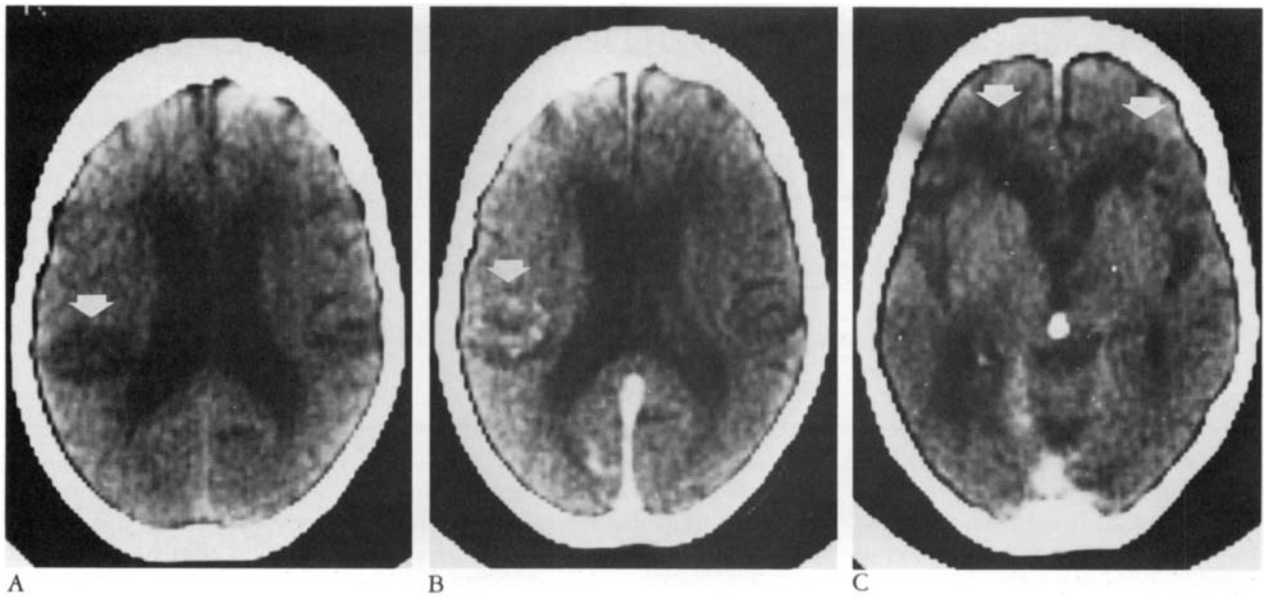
(Patient 1.) (A) Noncontrast computed tomographic (CT) scan at day 70, demonstrating a left parietal infarct (arrow). (B) Contrast CT scan at day 70, showing enhancement of the left parietal infarct (arrow). (C) Contrast CT scan at day 84, showing bifrontal periventricular white matter lucencies (arrows).
